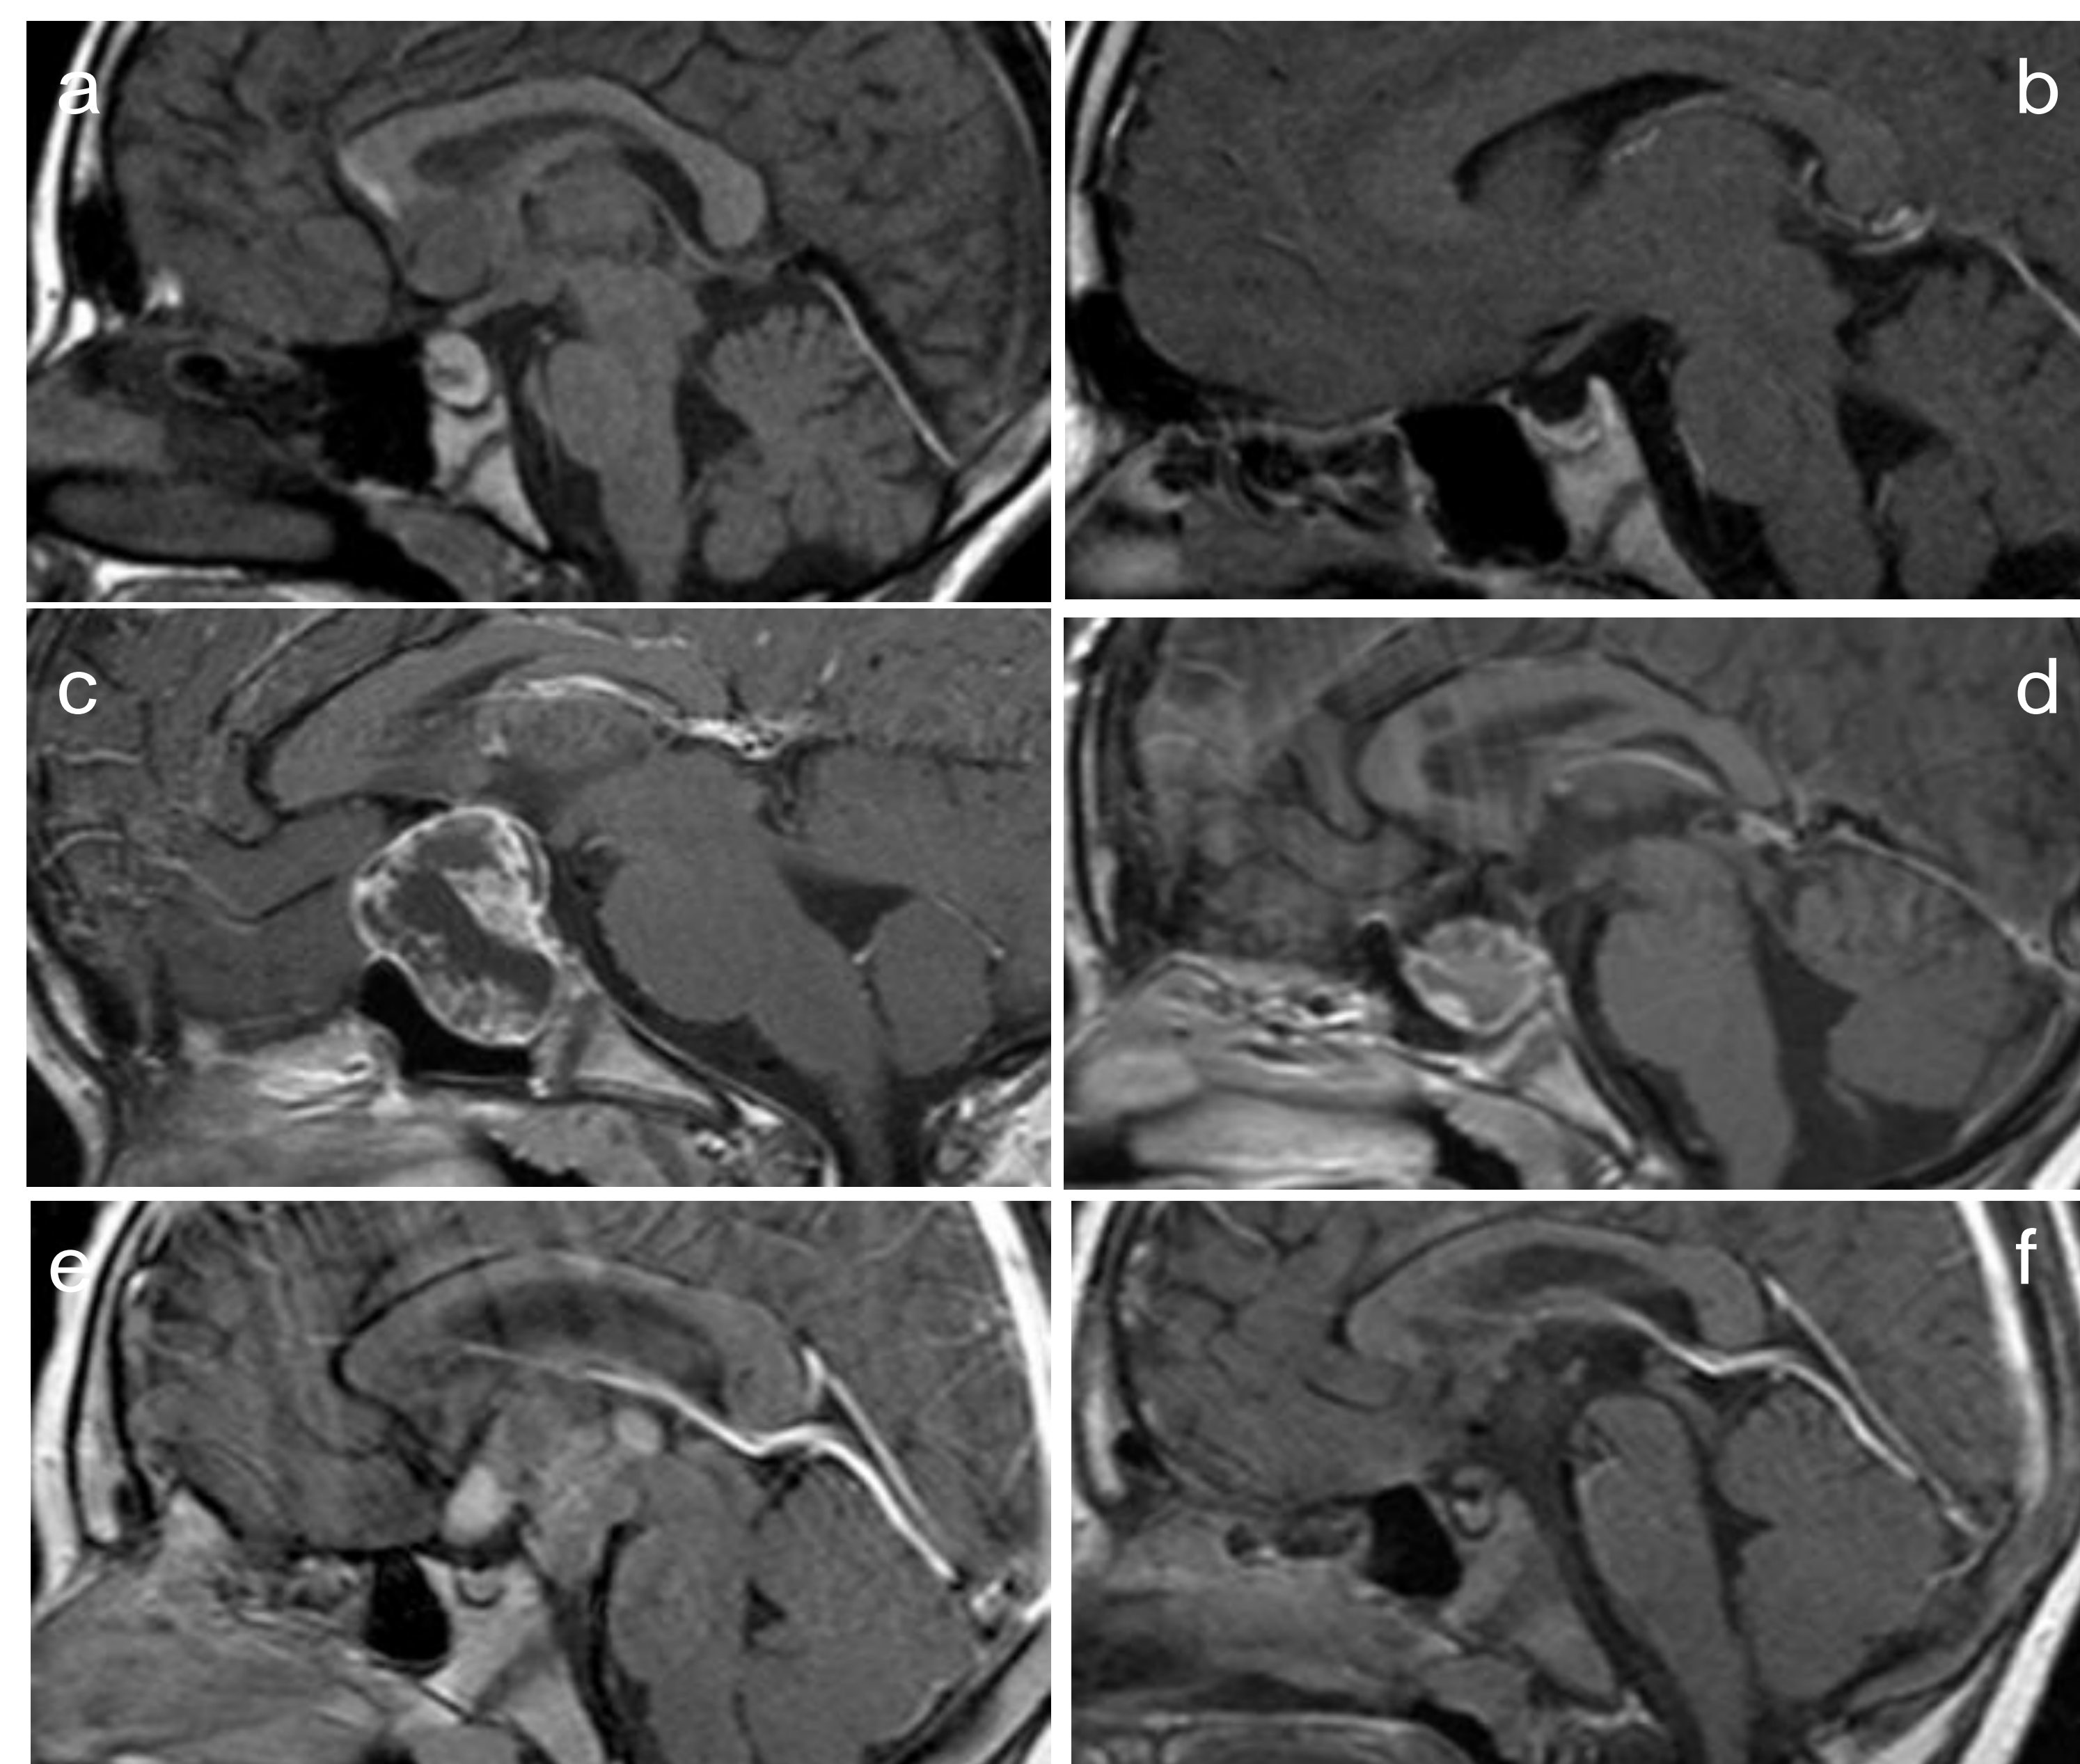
MRI at diagnosis and 36 months postOP in 3 CP with different degrees of preOP hypothalamic involvement (HI) and operative hypothalamic damage (HD). Figures 1a, b: sellar tumor (no HI [a]/no operative HD [b]) Figures 1c, d: preOP HI (c) and operative HD (d) of the anterior hypothalamus (not including the mammillary bodies). Figures 1e, f: preOP HI (e) und operative HD (f) of anterior+posterior hypothalamus areas (including the mammillary bodies).
